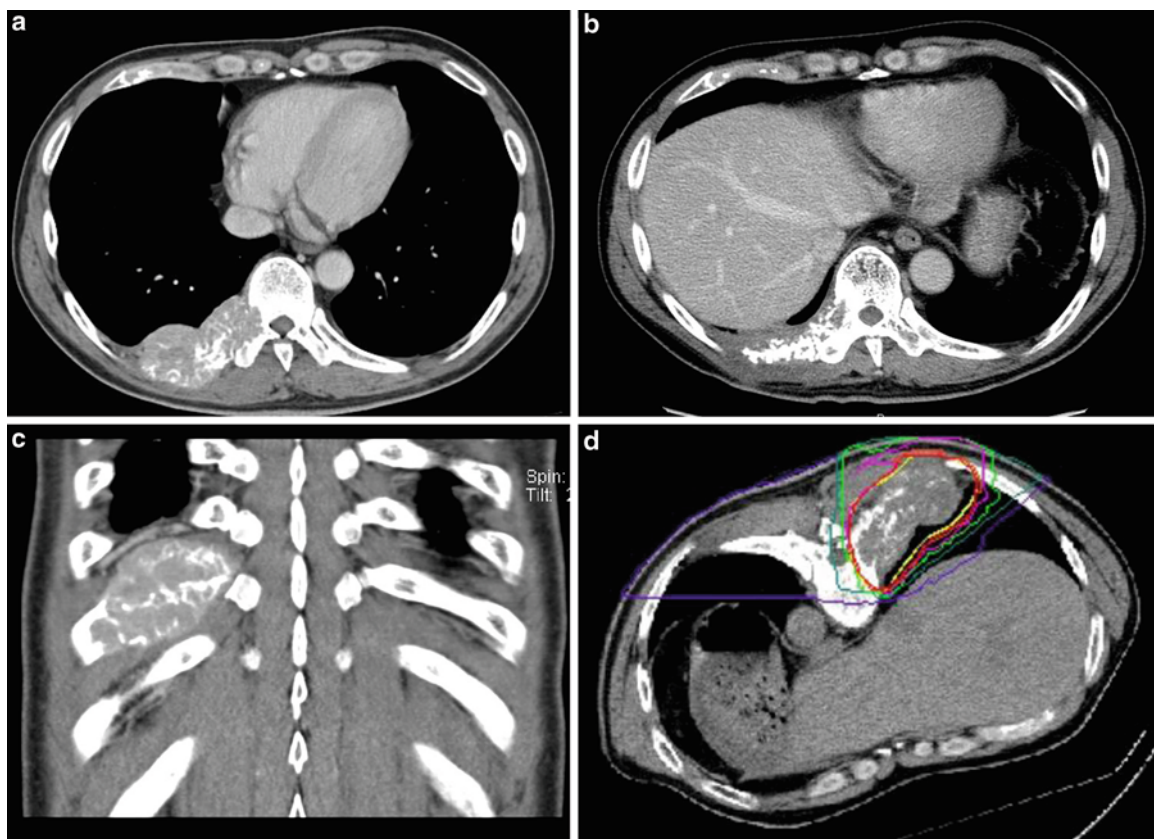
(a) CT image with a contrast medium before carbon ion radiotherapy. The tumor is located in the right tenth rib and he complained of back pain. (b) CT image with a contrast medium 8 years after carbon ion radiotherapy. The tumor shrank and partially calcified.
